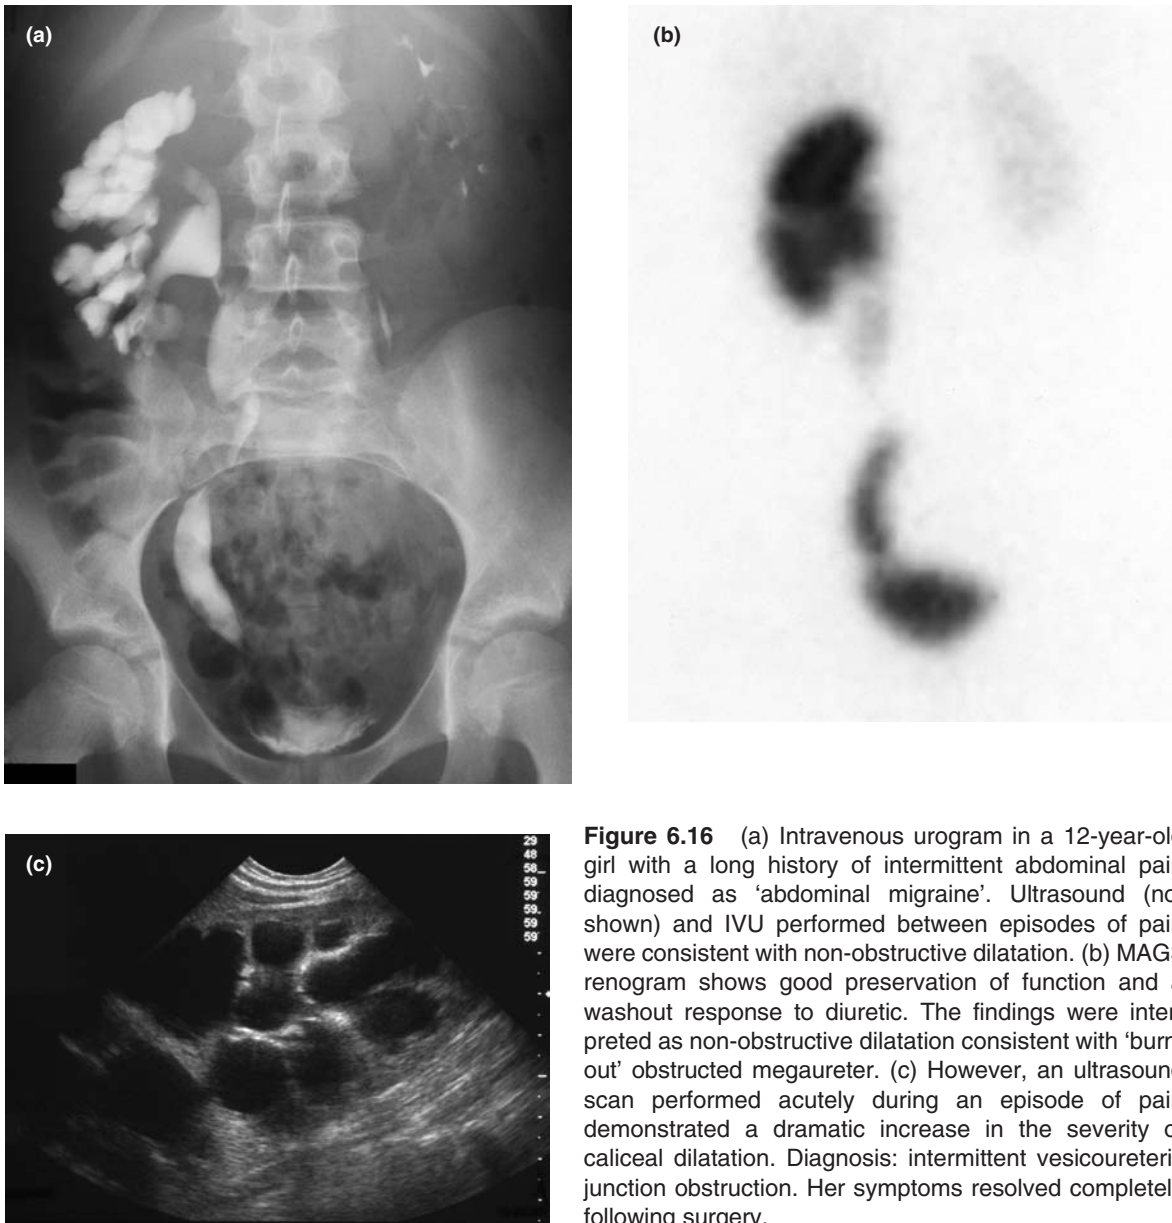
(a) Intravenous urogram in a 12-year-old girl with a long history of intermittent abdominal pain diagnosed as 'abdominal migraine'. Ultrasound (not shown) and IVU performed between episodes of pain were consistent with non-obstructive dilatation. (b) MAG3 renogram shows good preservation of function and a washout response to diuretic. The findings were interpreted as non-obstructive dilatation consistent with 'burnt out' obstructed megaureter. (c) However, an ultrasound scan performed acutely during an episode of pain demonstrated a dramatic increase in the severity of caliceal dilatation. Diagnosis: intermittent vesicoureteric junction obstruction. Her symptoms resolved completely following surgery.
